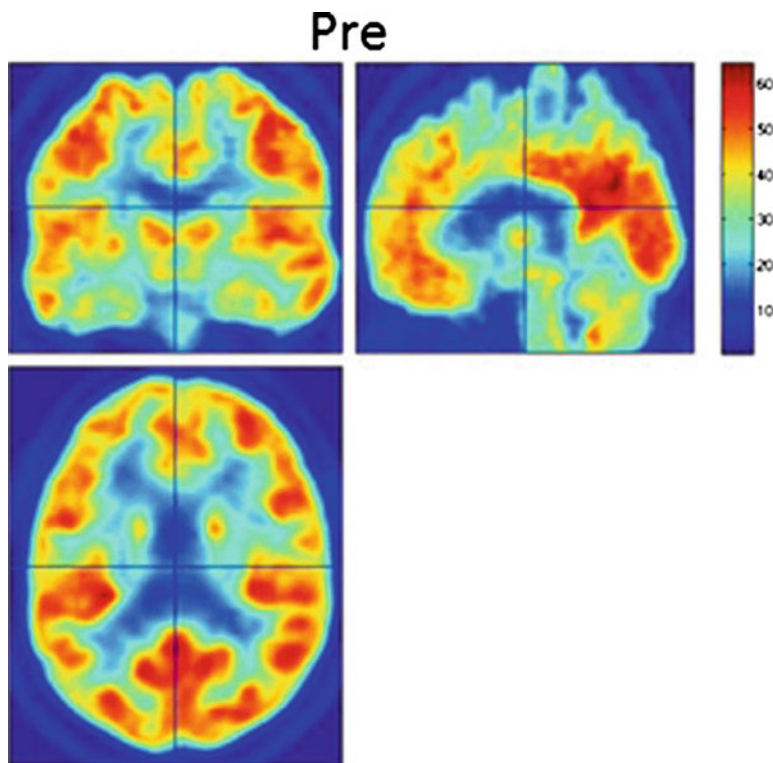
^{18}F FDG PET brain scan prior to starting psychotherapy (pre-treatment)
